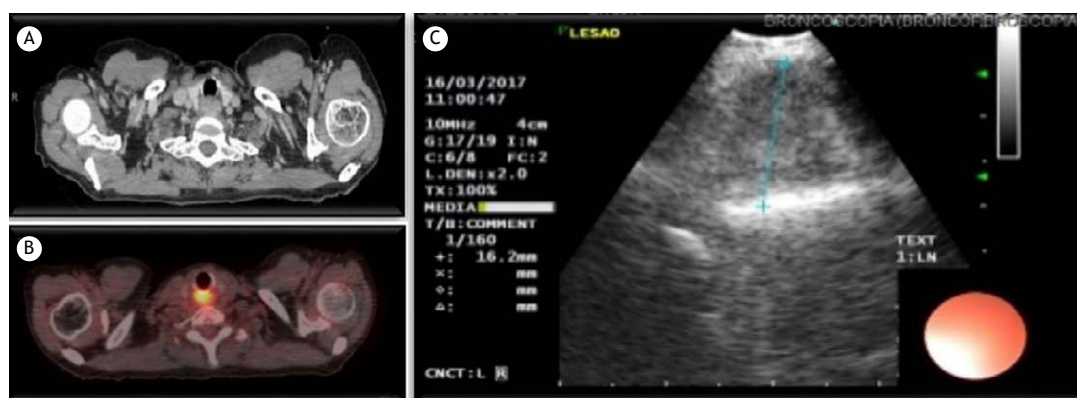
In A, CT scan of the neck and chest showing nonspecific thickening and mild heterogeneous enhancement at the pharyngoesophageal junction. In B, positron emission tomography scan showing circumferential thickening of the cervical esophagus leading to narrowing of the esophageal lumen (standardized uptake value, 9.6). Note the absence of signs of invasion into the adjacent structures. In C, endobronchial ultrasound showing a heterogeneous lesion with well-defined margins and no vessels at the subglottic level, where endobronchial ultrasound-guided transtracheal needle aspiration was performed.
